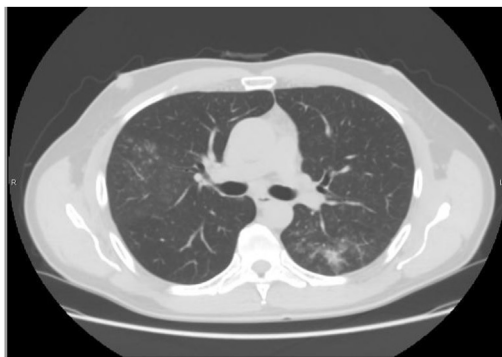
A, B: Axial and coronal views respectively. Initial chest CT scan showed a consolidation with air bronchograms, adjacent tree-in-bud nodules, no pleural effusions, and a patent airway.
